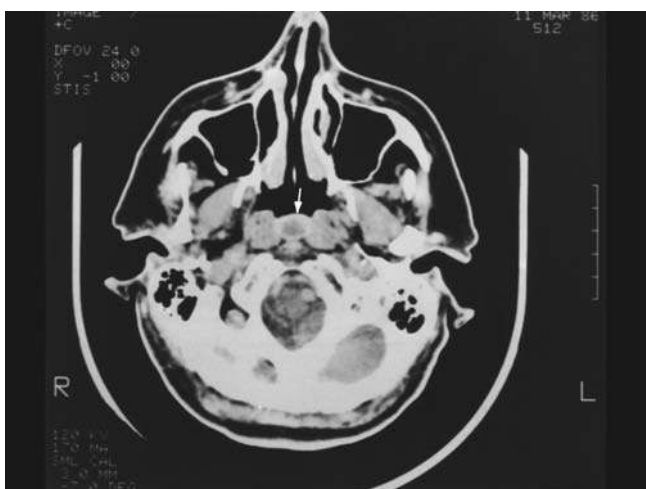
Axial CT scan showing a low-density, well-circumscribed Thornwaldt's cyst (*arrow*) between the longus capitis muscles. *Abbreviation:* CT, computer tomography. *Source:* From Ref. 7.
